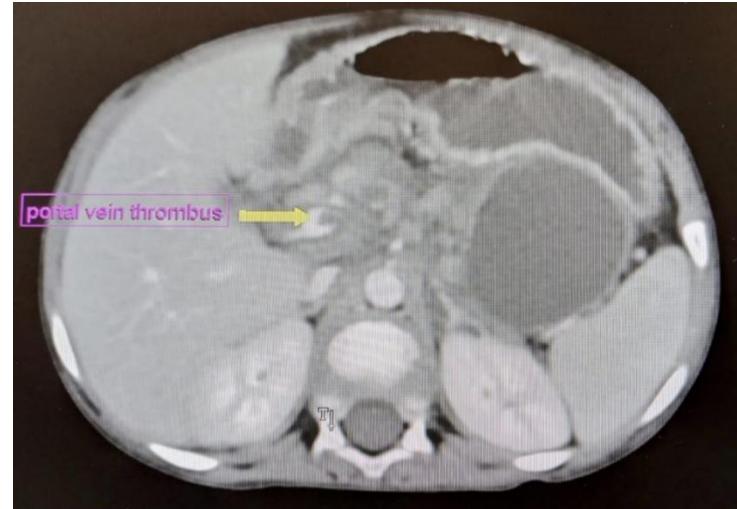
Axial contrast-enhanced CT scan showing peripancreatic fluid collections surrounding the pancreas, consistent with acute necrotizing pancreatitis
